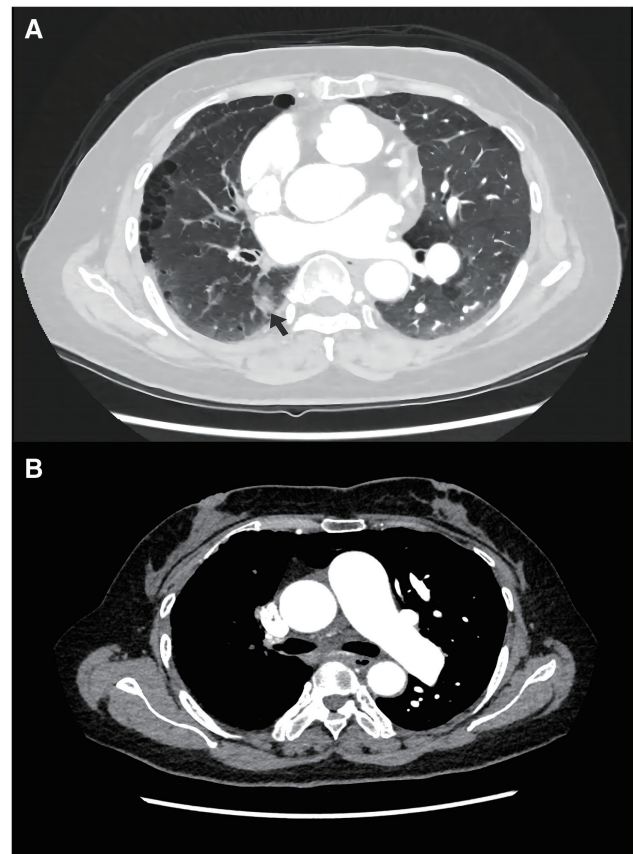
Chest CT of the patient. (A) A mixed ground-glass nodule was seen at the black arrow in the lower lobe of the right lung and (B) CT angiography of the pulmonary artery showed that the right pulmonary artery was absent and the left pulmonary artery was enlarged.
